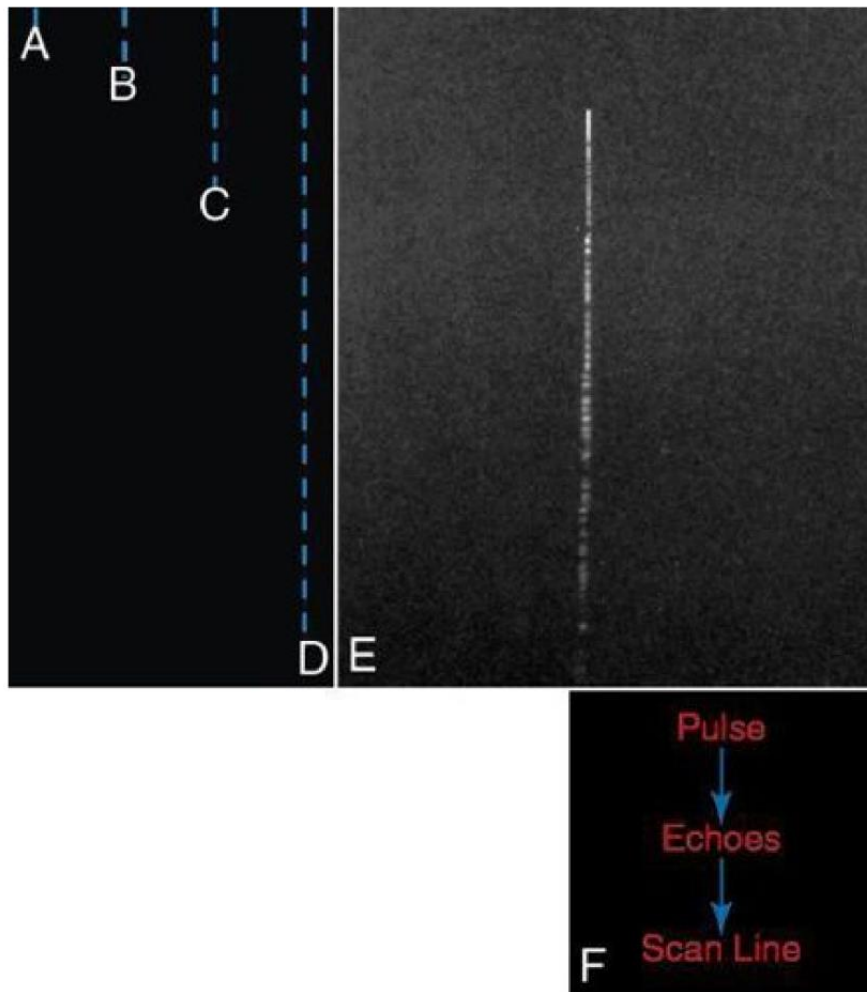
One pulse of ultrasound generates a single scan line (series of echoes) as it travels through tissue. Echoes are presented in sequence on a scan line while they return from tissue during pulse travel. A, The first echo is displayed. B, The second echo is added. C, Three more echoes are added. D, All the echoes from a single pulse have been received and displayed as a completed scan line. E, A complete scan line results from one emitted pulse. In practice, this is accomplished in less than one one-thousandth of a second. F, According to the pulse-echo imaging principle, one pulse traveling through tissues produces a stream of echoes that become one scan line on the display.
